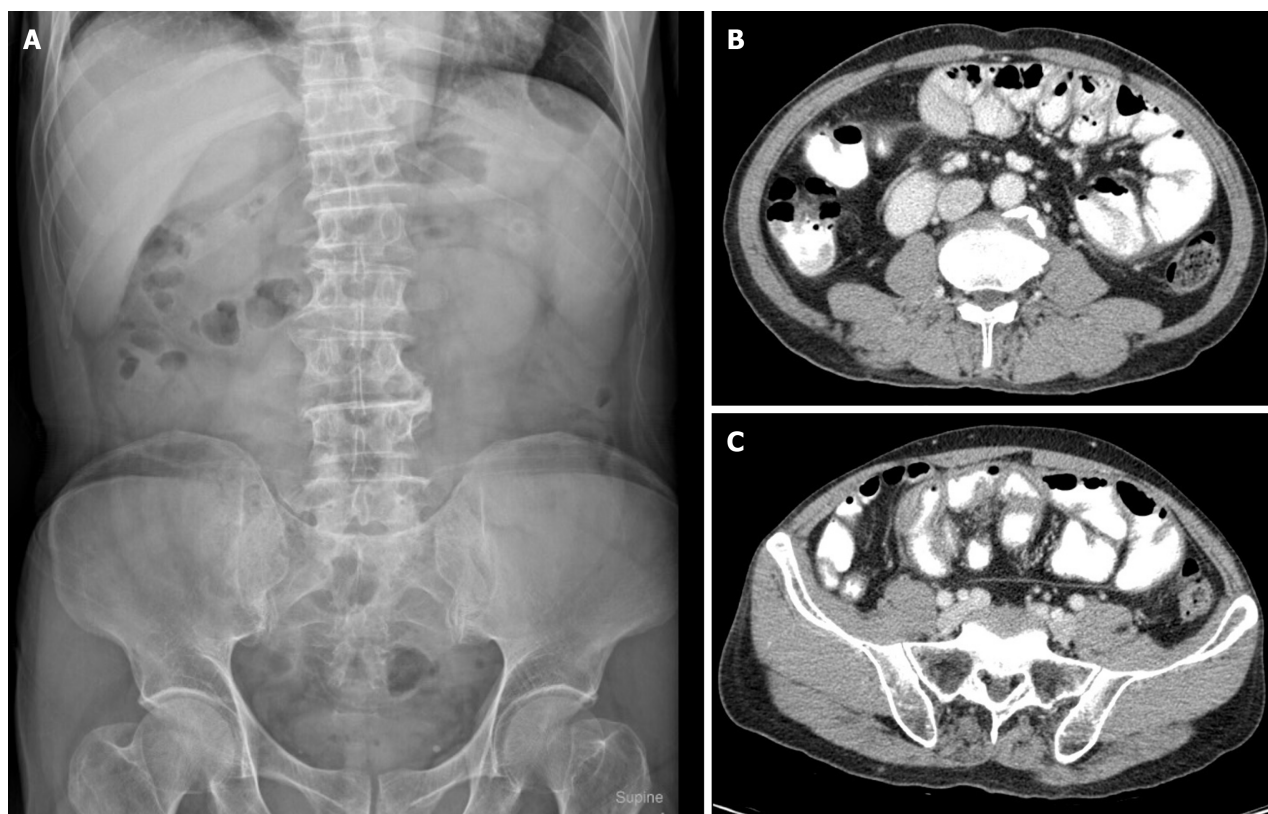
Abdominal X-ray and computed tomography whole abdomen with oral and IV contrast. A: Gasless small bowel; B and C: Stacking small bowel loops inside a thick membrane-like sac.
